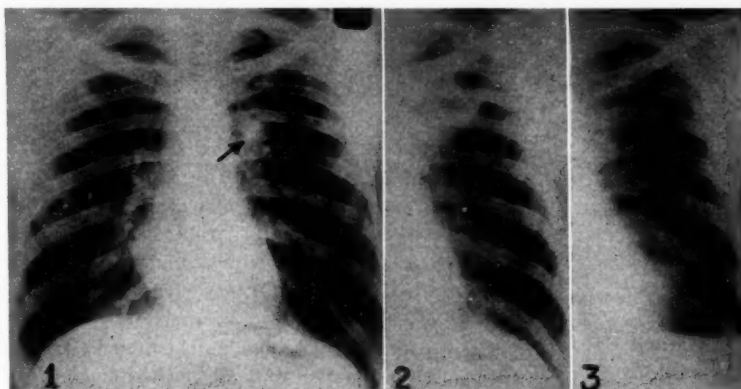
Case 1. Roentgenogram taken January 12, 1931. Note beginning shadow in left hilum.
